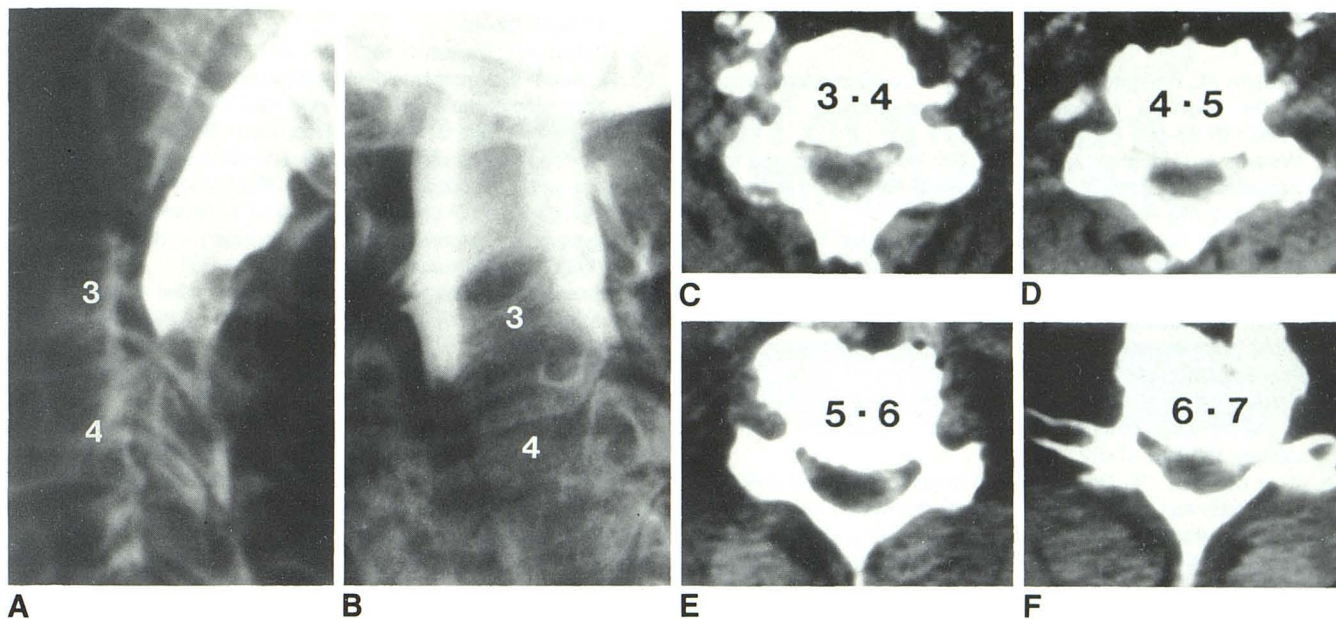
72-year-old woman with severe cervical myelopathy. Lateral (A) and posteroanterior (B) myelograms. Complete block at C3–C4. C, CT myelogram at C3–C4. Ventral spur obliterating ventral subarachnoid space. D, Canal stenosis is even more marked at C4–C5 level with secondary cord flattening.
